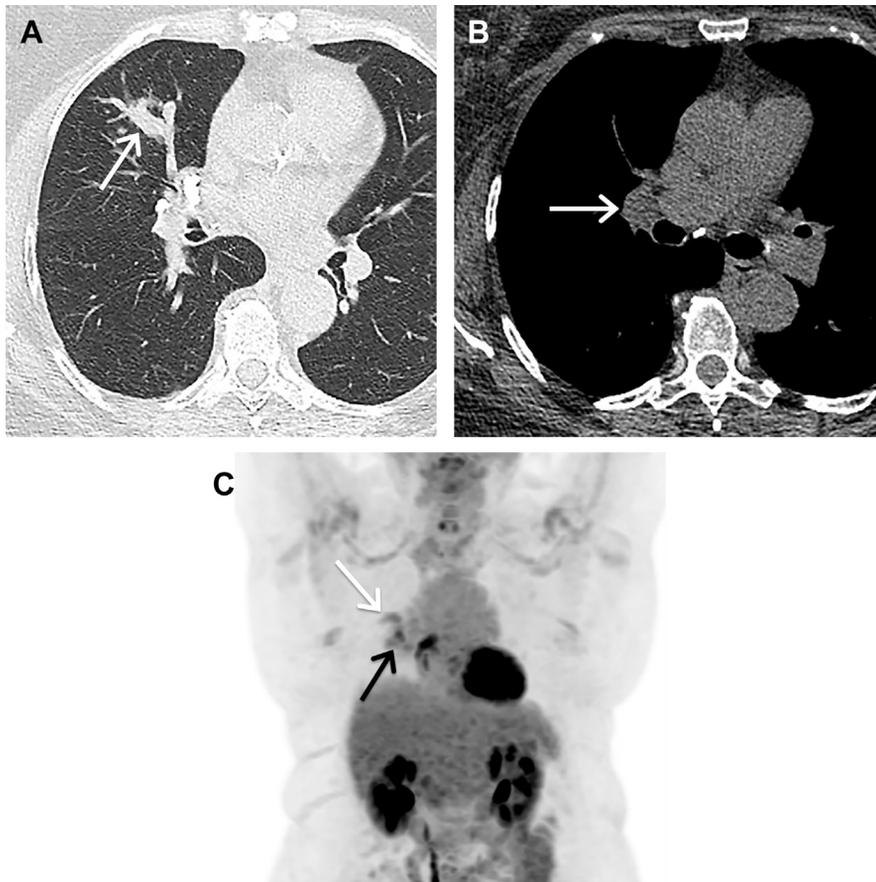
Baseline axial LDCT of a 74-year-old man on (A) lung and (B) soft tissue windows demonstrates an endobronchial nodule (A, arrow) in the middle lobe that expands the bronchus and an enlarged right hilar lymph node (B, arrow) suspicious for lymph node metastasis. Although an endobronchial nodule is typically given a Lung-RADS category of 4A, the presence of suspicious right hilar lymphadenopathy increased clinical concern for lung cancer; thus, a Lung-RADS category of 4X was assigned. (C) Whole body FDG-PET image subsequently obtained shows increased FDG uptake in the endobronchial lesion (white arrow) and right hilar lymph node (black arrow). Biopsies confirmed lung cancer and ipsilateral hilar lymph node metastasis.
